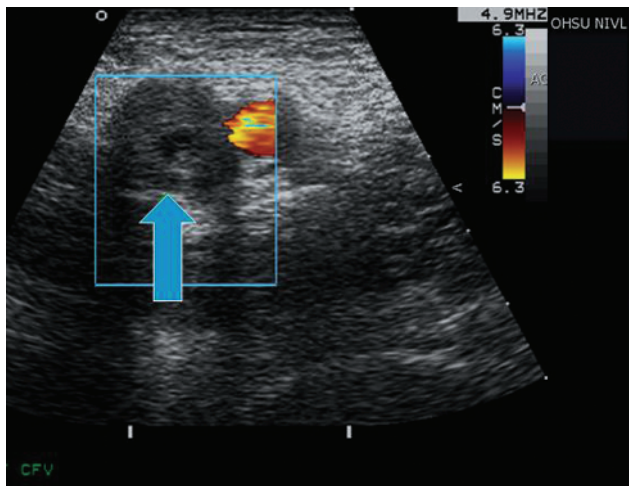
Failure of the common femoral vein to compress with pressure applied by the ultrasound scanhead indicates the presence of thrombus in the common femoral vein. As in this case, the acutely thrombosed vein is often enlarged and there is absence of collateral veins.
